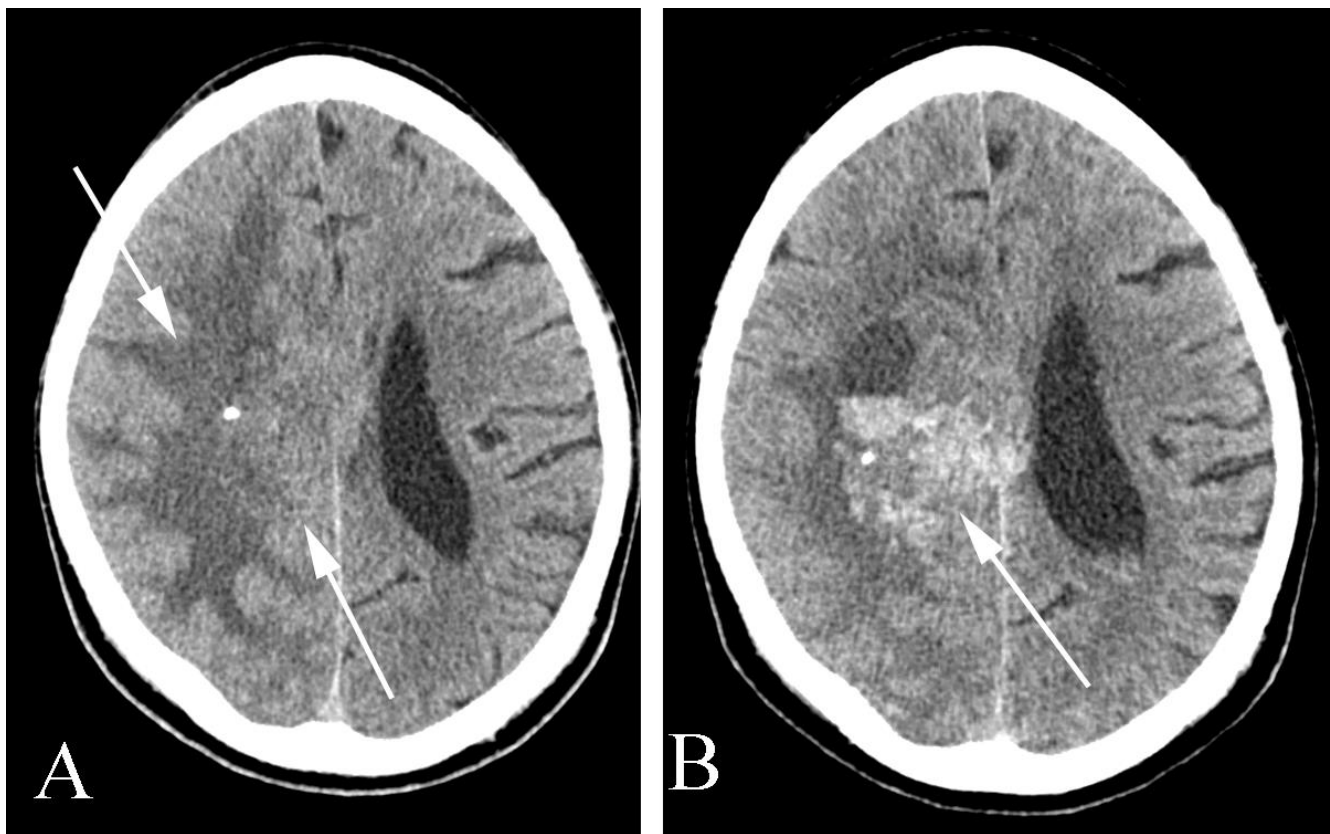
Intraparenchymal hemorrhage in a 40 year old man with a headache and a known right hemisphere oligodendroglioma. A. Axial unenhanced CT done prior to the headache as part of tumor monitoring shows a mass effacing the right lateral ventricle (arrows). B. Axial unenhanced CT done after the onset of a new headache demonstrates hemorrhage into the tumor (arrow).
